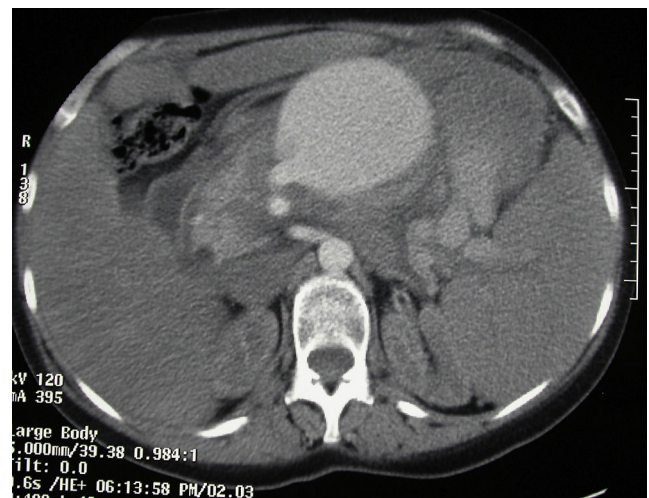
Aneurysm of the splenic artery on abdominal CT scan.
